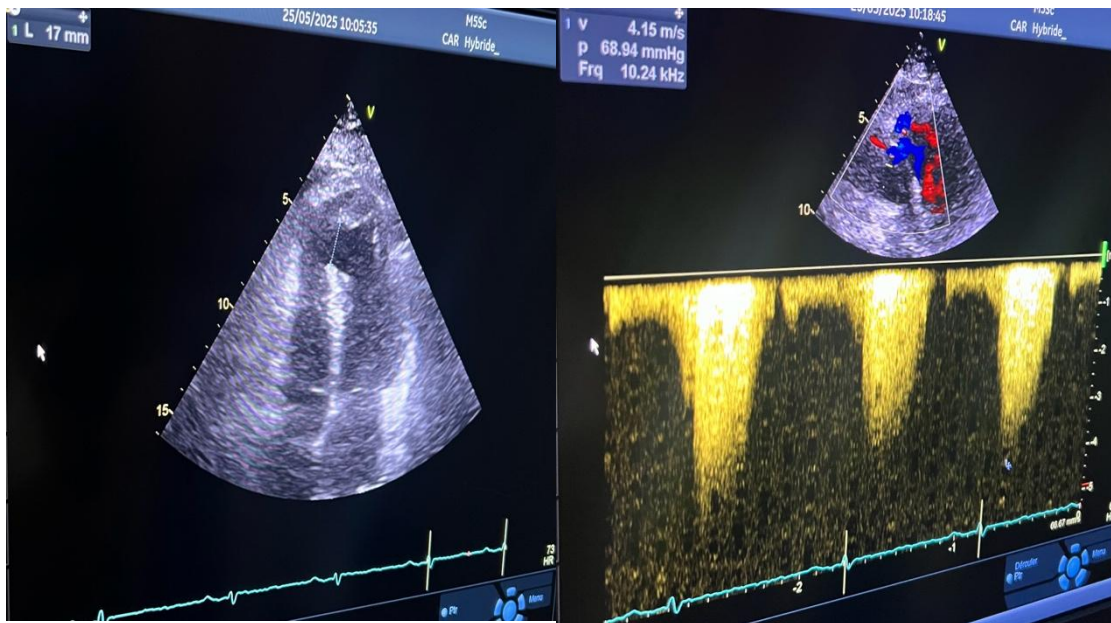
Transthoracic echocardiography showing a 17-mm muscular septo-apical ventricular septal defect with a left-to-right shunt and a peak continuous-wave Doppler gradient of 68 mmHg
